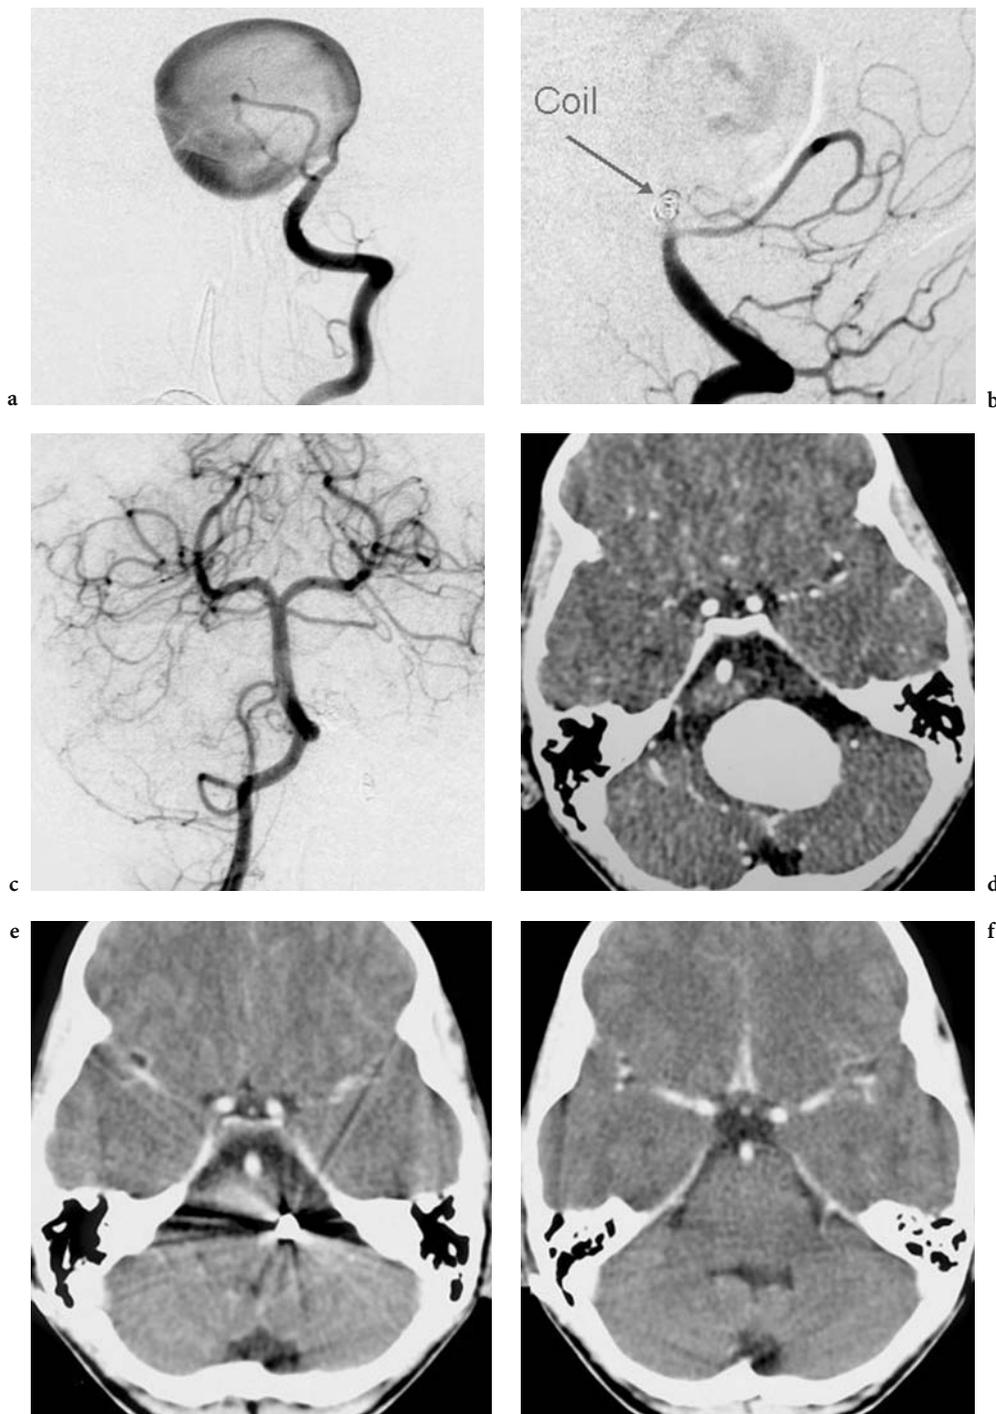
a PA view. Giant vertebral artery aneurysm in a 9-year-old boy presenting with dizziness, vomiting and nausea. b Lateral view. Endovascular occlusion of the left vertebral artery was performed distal to the PICA using one GDC-Vortx-Coil. c Injection into the contralateral vertebral artery revealed no retrograde filling of the aneurysm. CT: (d) before and (e, f) 6 months after vessel occlusion demonstrated complete retraction of the aneurysm
